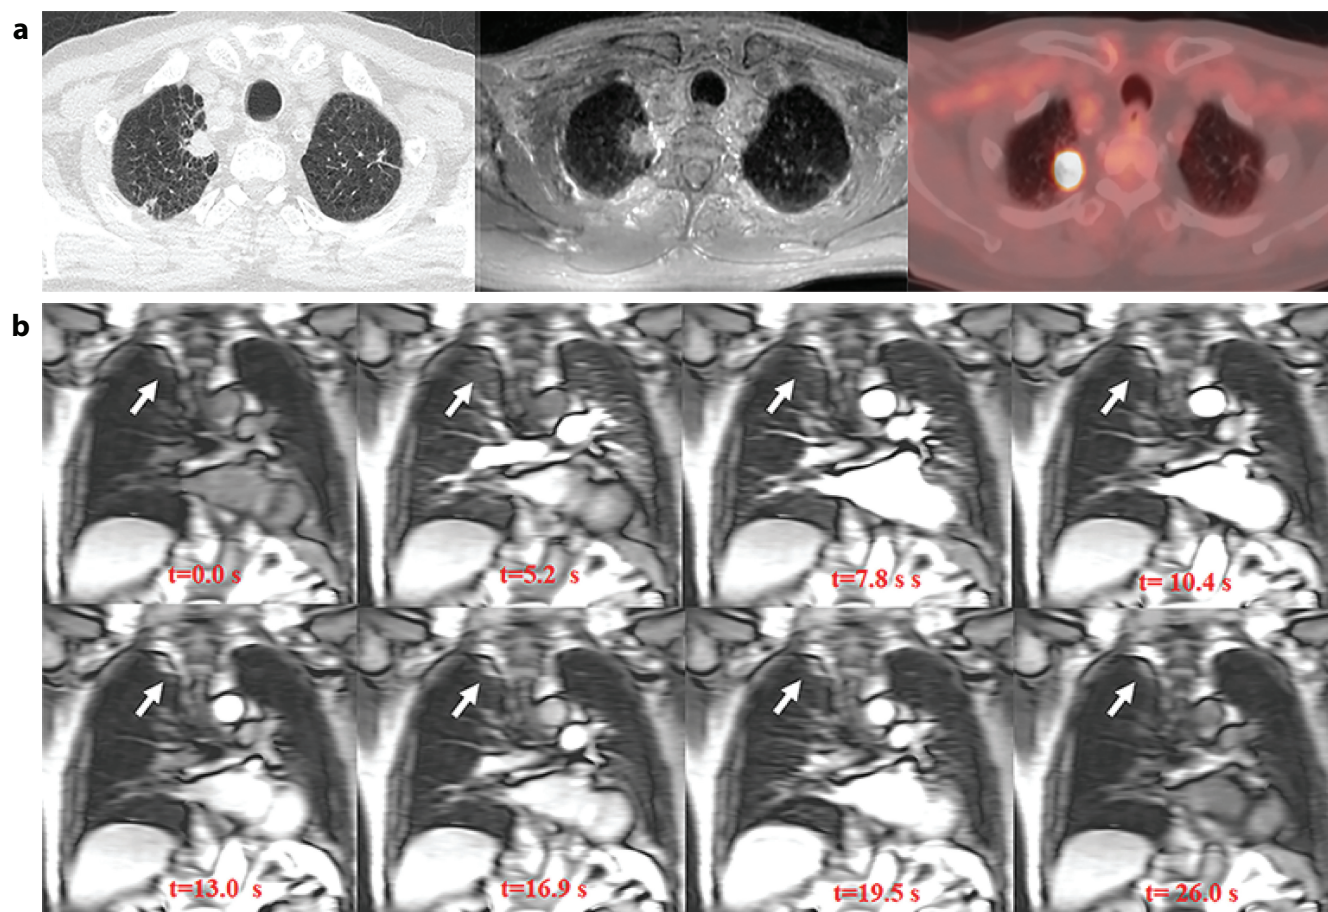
Images in 82-year-old man with invasive adenocarcinoma in right upper lobe. a: Thin-section CT scan with 1-mm-thick sections (left), pulmonary MRI scan with ultrashort echo time at 110 msec and 1-mm-thick sections (middle), and fluorine 18 FDG PET/CT scan with 2.5-mm-thick sections (right). CT and MRI scans show solid nodule with notch. This nodule demonstrates high FDG uptake on PET/CT scan. CT and MRI scans also show bullae and emphysematous lung surrounding tumor. b: Dynamic first-pass contrast material-enhanced perfusion gradient-echo MRI scans obtained with a 3-T system demonstrate well-enhanced nodule (arrows) in right upper lobe. This nodule shows enhancement from lung parenchymal phase and is well enhanced at systemic circulation phase. t is the time after injection of gadolinium-based contrast agent followed by saline chaser. (Reproduced, with permission, from reference No. 2) FDG, fluorodeoxyglucose.
